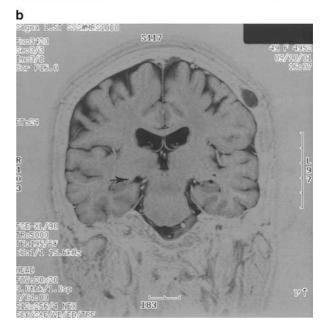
MRI heavily T2 weighted image (reverse image) demonstrates low intensity (arrowhead) around the right lateral geniculate body: (a) transverse image, (b) coronal image.
